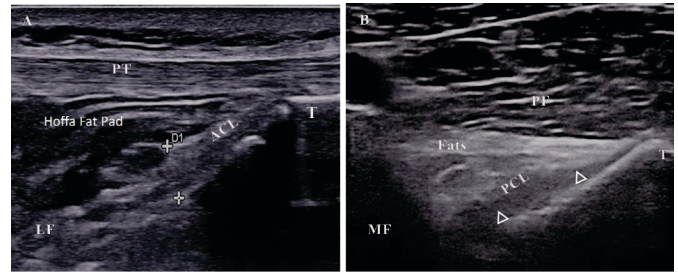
Point-of-care ultrasound examinations of the nontraumatic knee. (A, B) Long-axis view of the normal anterior cruciate ligament (cursors, A) and posterior cruciate ligament (arrowheads, B). Continuity, with well-defined hypoechoic bands, is well preserved. PT = patella Tendon; T = tibia; LF = lateral femoral condyle; MF = medial femoral condyle; PF = Popliteal Fossa.
